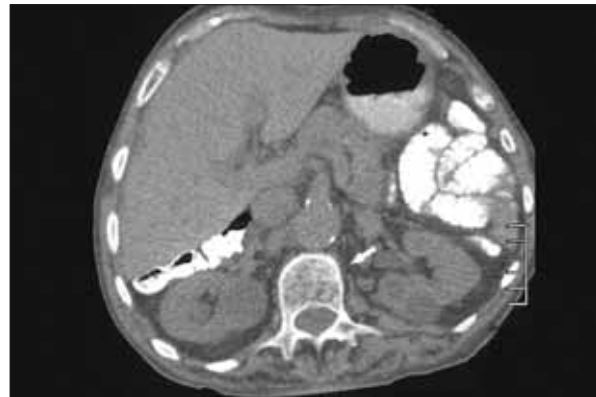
Axial non-contrast CT of the abdomen shows defect of the left posterior diaphragmatic crus
